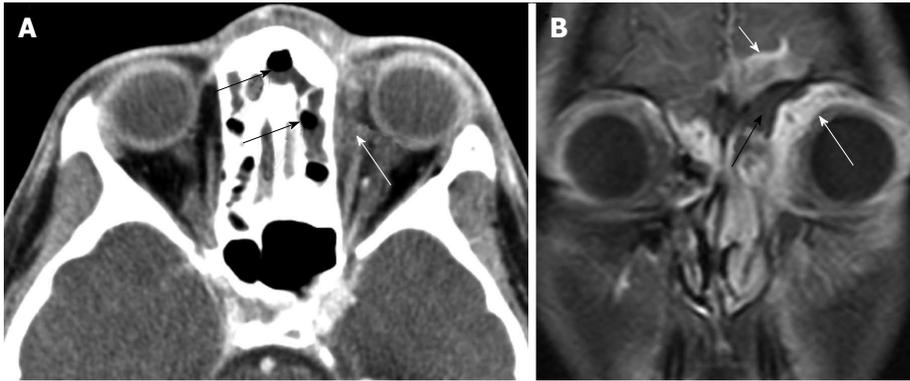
Infectious orbital cellulitis. A: Axial CT showing layering fluid in the ethmoid sinus and frontal recess on the left (black arrows), and infiltration of the orbital fat (white arrow); B: Coronal T1 fat saturated post-gadolinium MRI demonstrates orbital fat infiltration (long white arrow). Fluid in the adjacent ethmoid sinus (black arrow) and intracranial extension of the process (short white arrow) are also features that indicate infection rather than orbital inflammatory disease. CT: Computed tomography; MRI: Magnetic resonance imaging.
